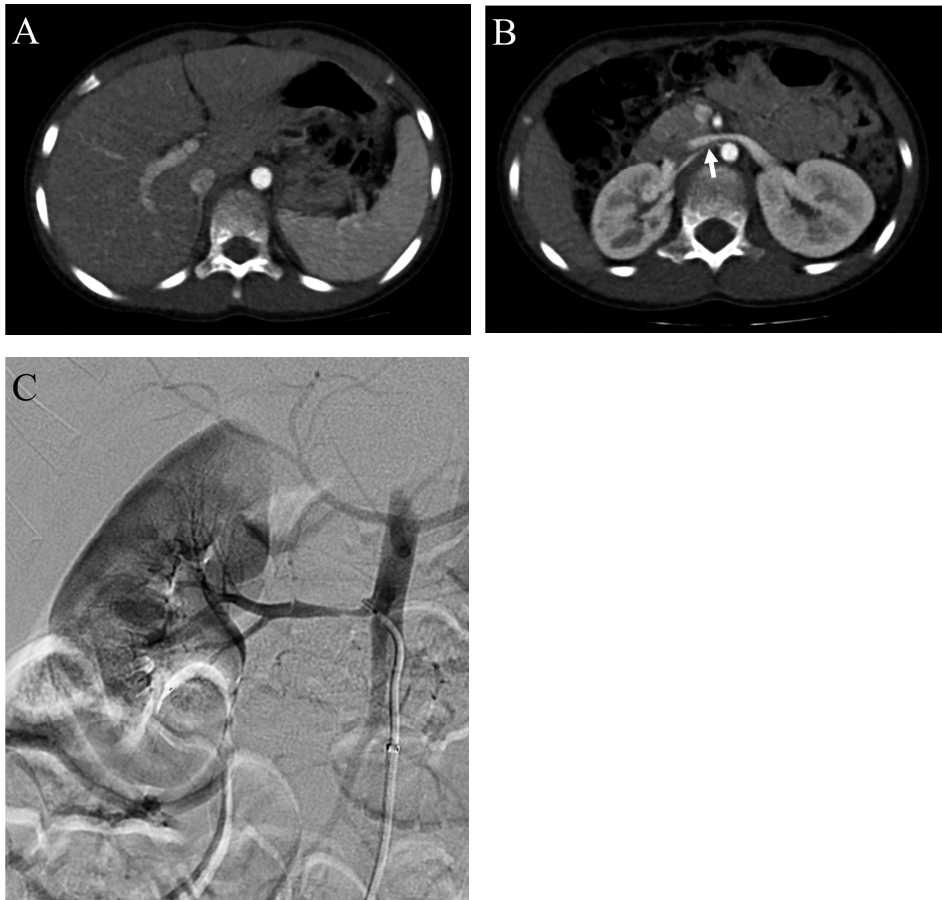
Representative abdominal computed tomography (CT) images obtained from an 8-year-old boy with hypertension using the split-bolus technique. (A) Adequate aortic, inferior vena caval, and portal venous opacification is achieved, as is good hepatic and renal parenchymal enhancement. (B) A stenosis (arrow) at the right proximal renal artery is well depicted, which was the cause of the patient's hypertension. (C) Renal artery stenosis was confirmed on conventional angiography for balloon angioplasty.
